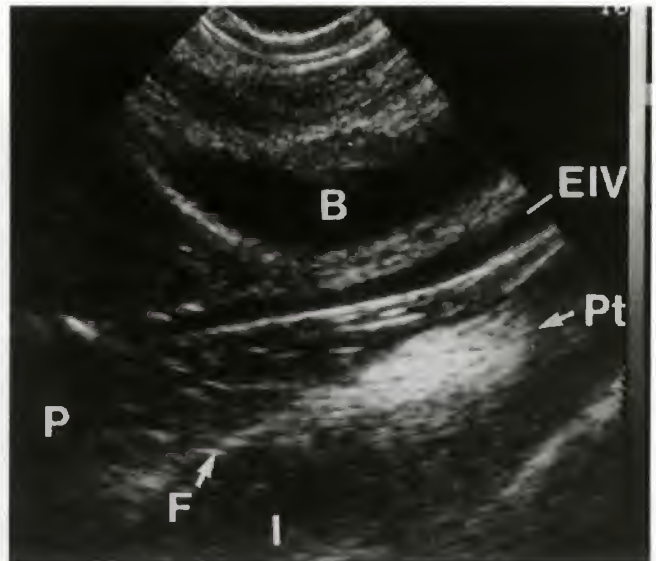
Transverse sonogram through the pelvic side wall angled to the right to visualize the psoas major (P), the iliacus muscle (I), and the psoas tendon (Pt). The external iliac artery (EIA) and vein (V) are anterior to the iliopsoas muscle bundle.
